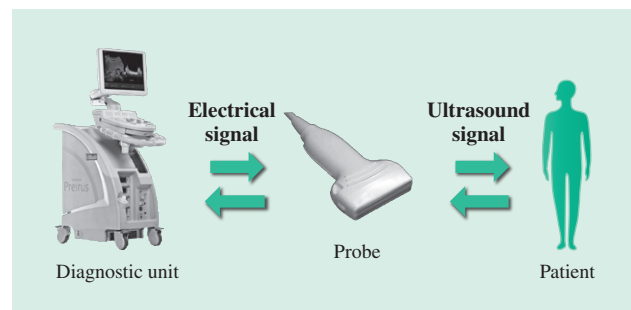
Principles and Components of Diagnostic Ultrasound Systems.
